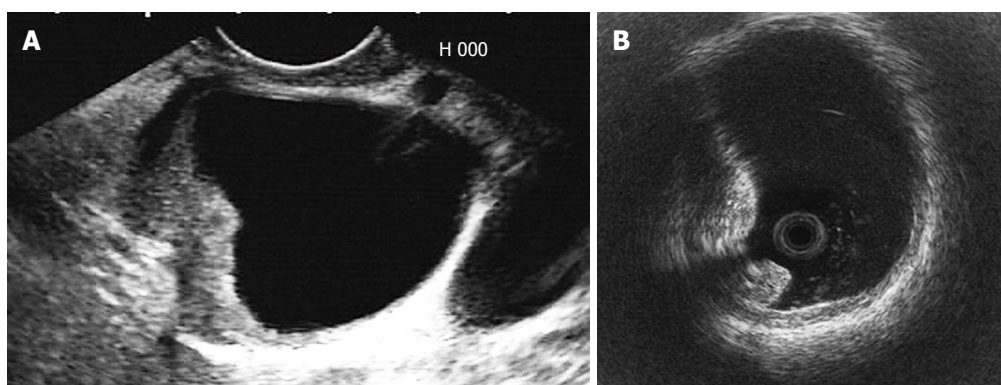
Ultrasonography of a congenital choledochal cyst patient with bile duct cancer in the dilated bile duct. A: Endoscopic ultrasonography; B: Intraductal ultrasonography.
